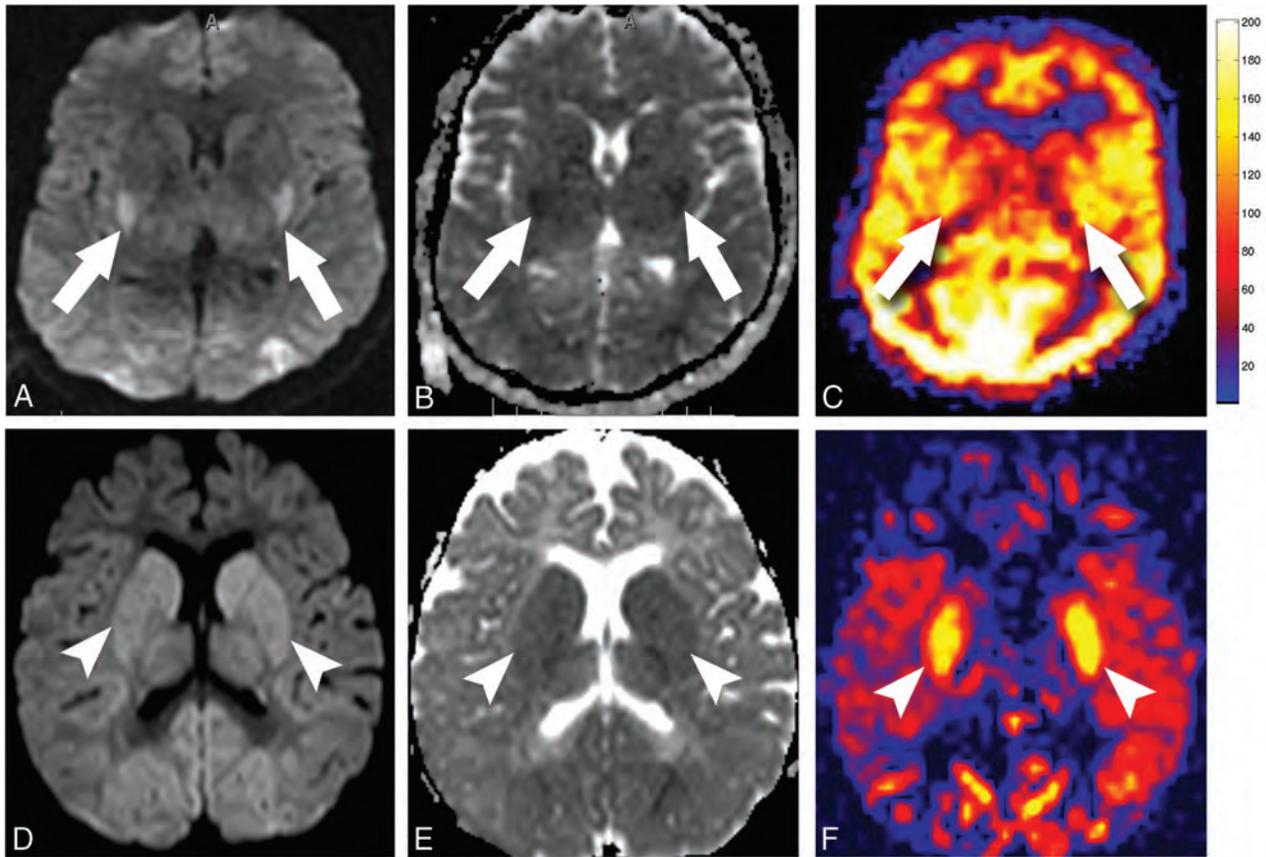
Quantitative-versus-nonquantitative ASL perfusion in anoxic brain injury. A–C, Quantitative perfusion imaging in a 31-year-old patient who had an anoxic brain injury after cardiac arrest. B = 1000 DWI (A) and ADC map (B) show diffusion restriction in the posterior putamen (arrows) and occipital cortex. C, Quantitative pulsed ASL image shows global hyperperfusion. Subtle increased cerebral blood flow is seen in the posterior putamen and occipital lobes, corresponding to the areas of diffusion restriction (arrows). D–F, Nonquantitative perfusion imaging in a 22-month-old child who had an anoxic injury after cardiac arrest. B = 1000 DWI (D) and ADC map (E) show diffusion restriction in the basal ganglia (arrowheads) and occipital cortex. F, Nonquantitative colorized pulsed ASL image demonstrates marked increases in the ASL signal in the putamen (arrowheads) and occipital cortex, corresponding to the areas of diffusion restriction.
